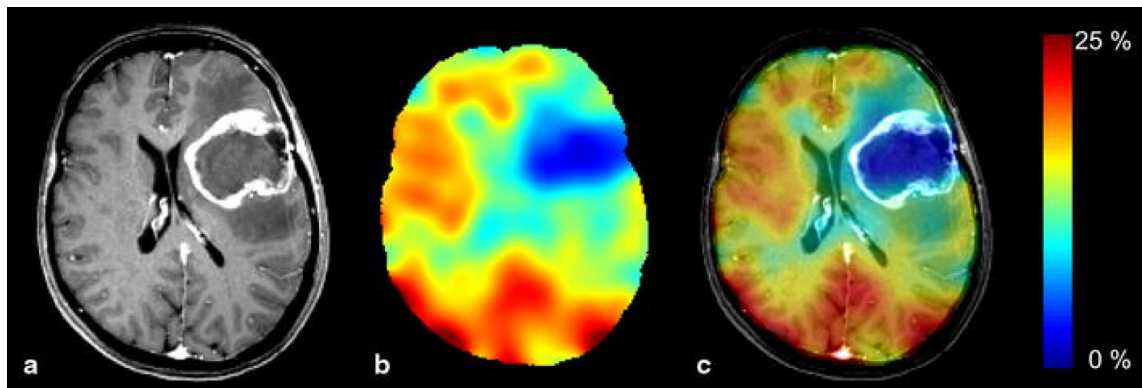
(a) Anatomical ^1H image (T1-weighted MPRAGE) of a glioblastoma after contrast media administration with typical ring enhancement. (b) Parameter map of the relative ^{17}O signal increase in the corresponding slice after $^{17}\text{O}_2$ inhalation. (c) Colored overlay of the signal increase and the registered ^1H data for anatomical reference. The central necrotic region of the tumor coincides well with the area of lowest ^{17}O signal increase of <2%. The highest gain in intensity was found in regions with a high gray matter fraction. Reproduced from [402]. With permission of Springer.
